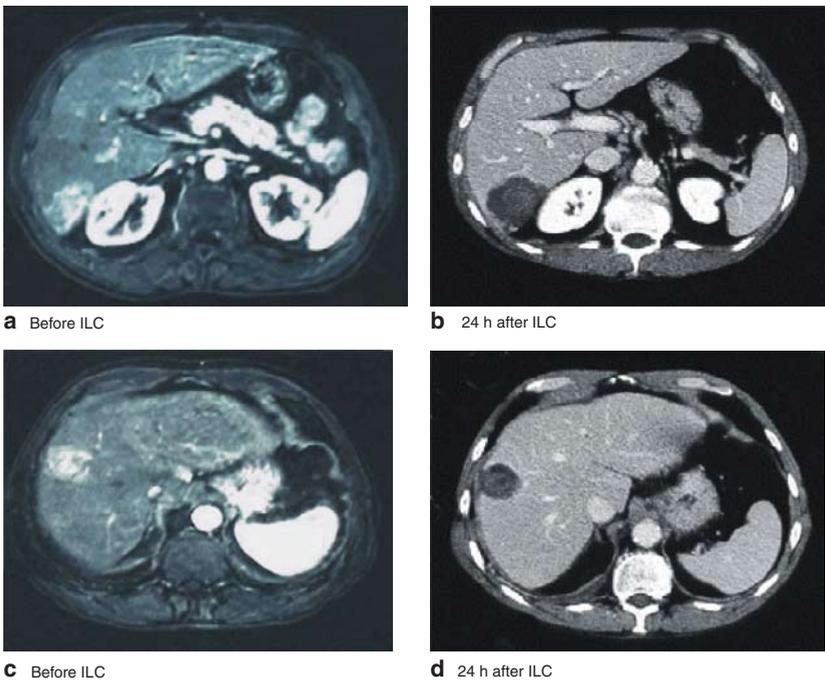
Computed tomograms of two nodules of hepatocellular carcinoma in one patient. a and c Images obtained before interstitial laser coagulation (ILC) with temporary hepatic artery occlusion. b and d Nodules in a and c respectively 24 h after ILC with temporary hepatic artery occlusion
